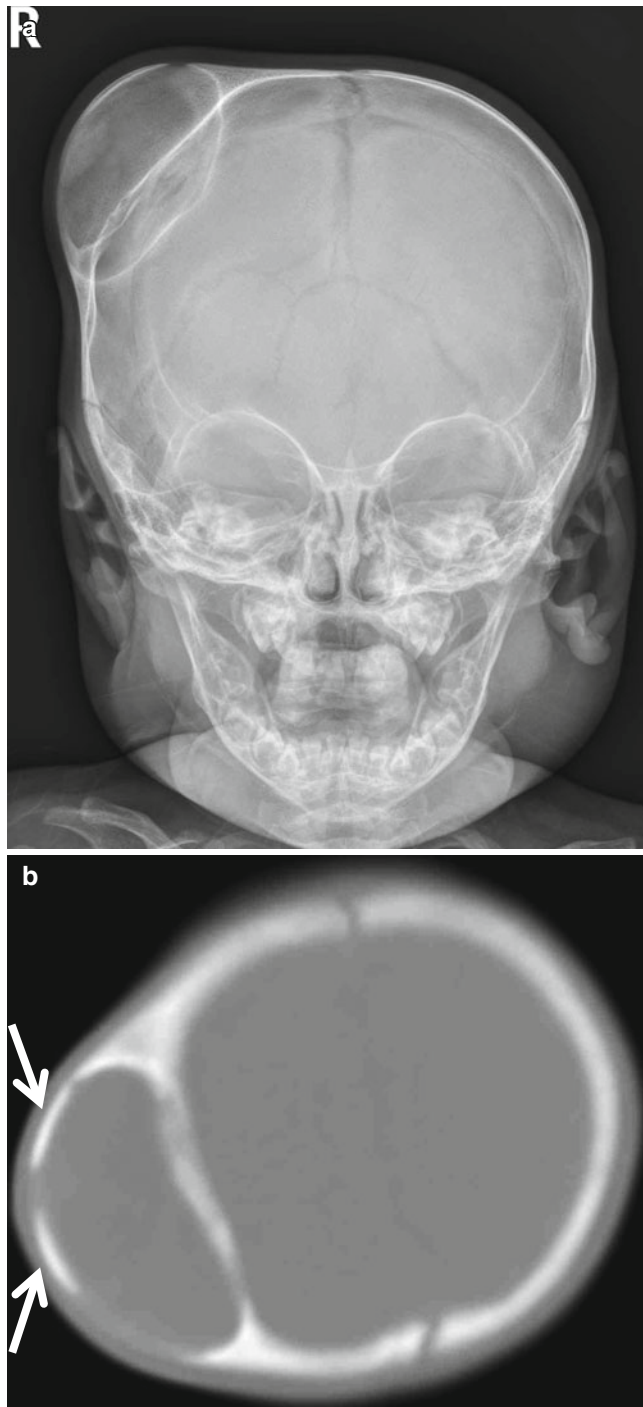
Calcified cephalhematoma. (a) Skull radiography shows calcified bulging mass adjacent to the right parietal bone. (b) CT shows outer periosteal layer of the cephalhematoma has calcified (arrows)
